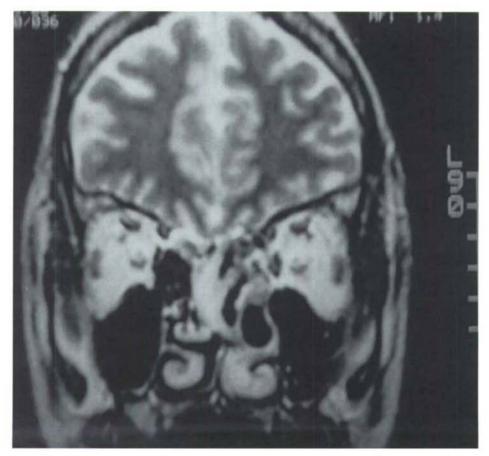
T2 weighed MRI of the same patient seen in Figure 4 showing the characteristic hypointense center.
